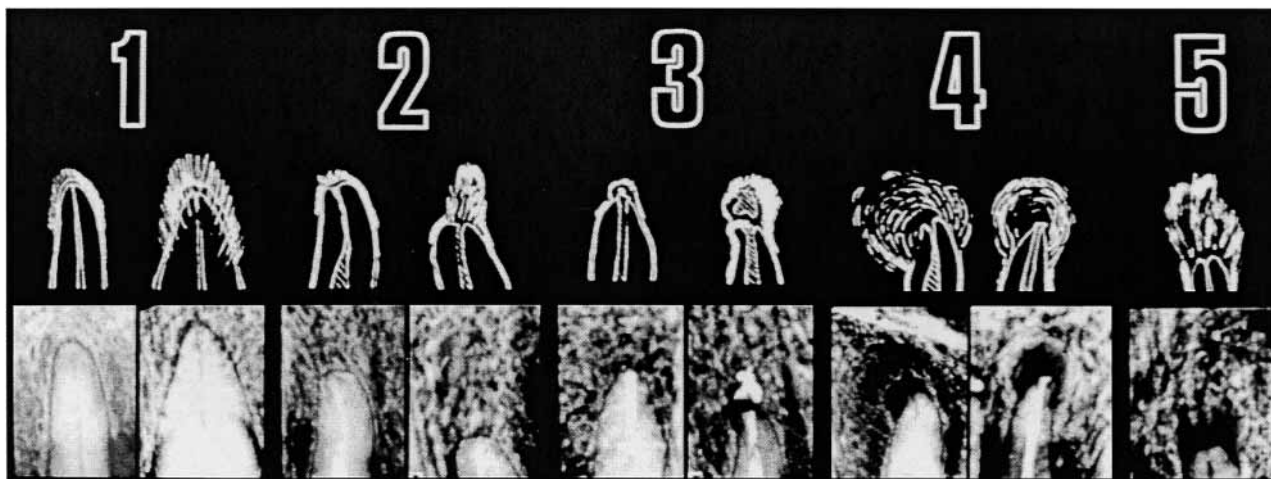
The periapical index. 1, Normal periapical structures 2, Small changes in bone structure. 3, Changes in bone structure with some mineral loss. 4, Periodontitis with well-defined radiolucent area. 5, Severe periodontitis with exacerbating features. Reproduced with permission from (54)
